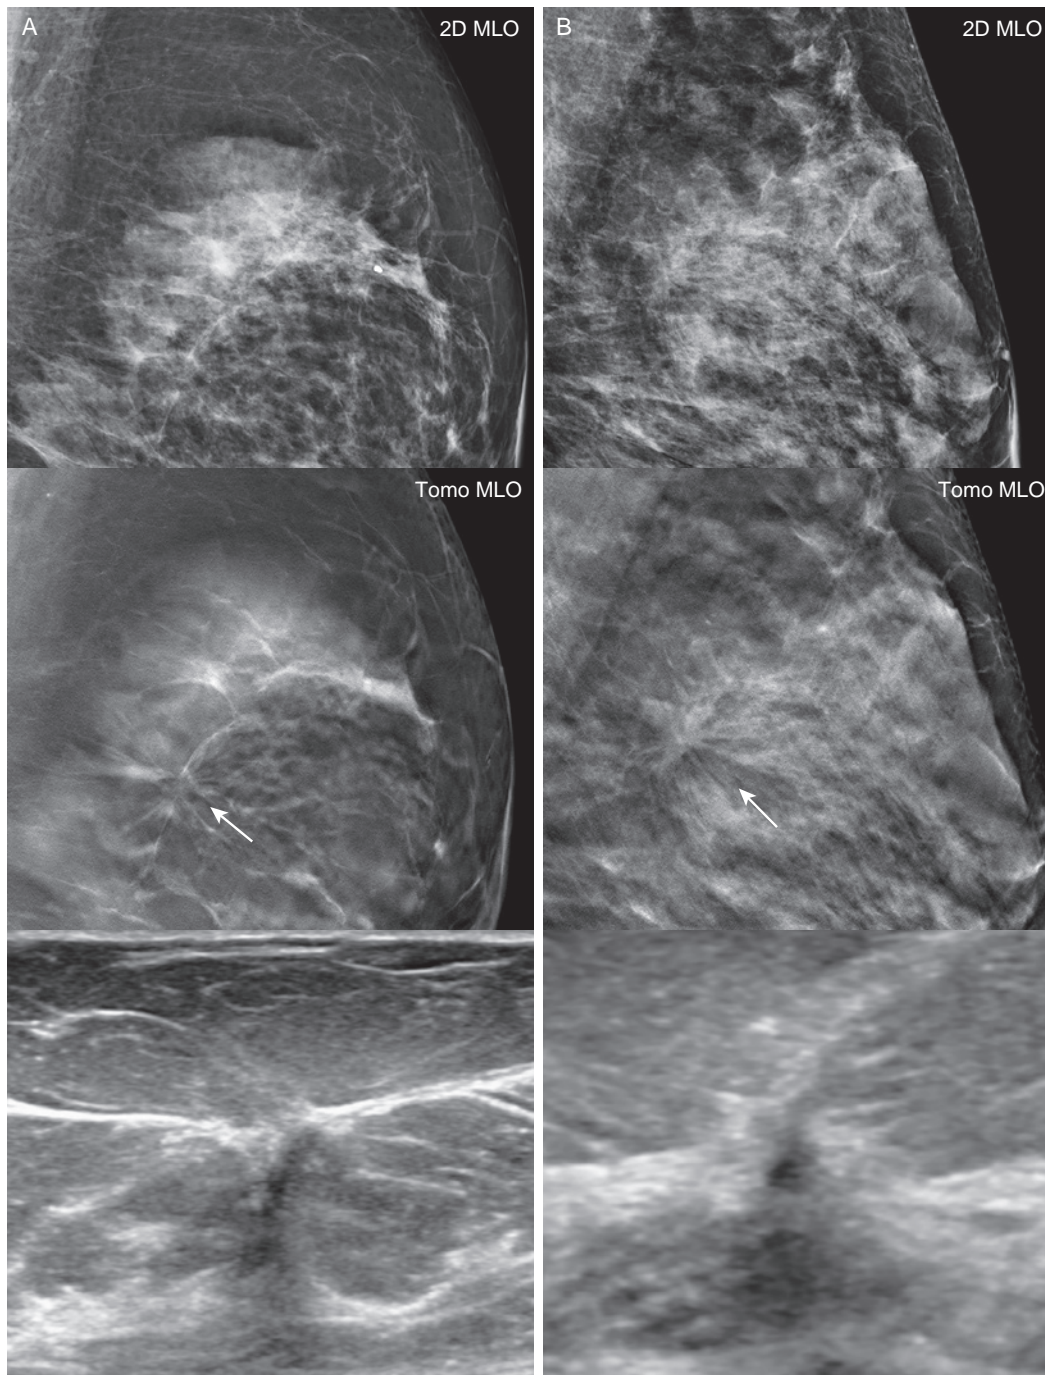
Benign and malignant architectural distortion may look identical on tomosynthesis and ultrasound. (A and B) MLO views in two separate patients show a subtle AD seen only on tomosynthesis (*arrows*). In both cases, targeted ultrasound reveals a corresponding irregular hypoechoic mass. Ultrasound-guided core needle biopsy = Patient A: 1.8 cm IDC, grade 1, ER/PR+, Her2+, Ki67 = 3%, 0/1 SLN. Patient B: Complex sclerosing lesion, confirmed with excision.
